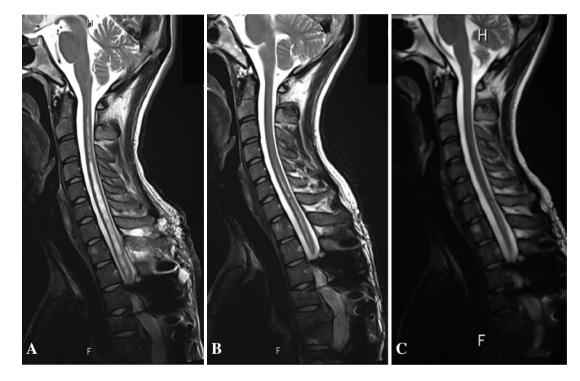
MRI at 1 week (A), 6 months (B), and 2 years (C) after surgical treatment with SS shunt, showing that shrinkage of the syrinx was achieved and preserved. MRI: magnetic resonance imaging, SS: syringosubarachnoid.
